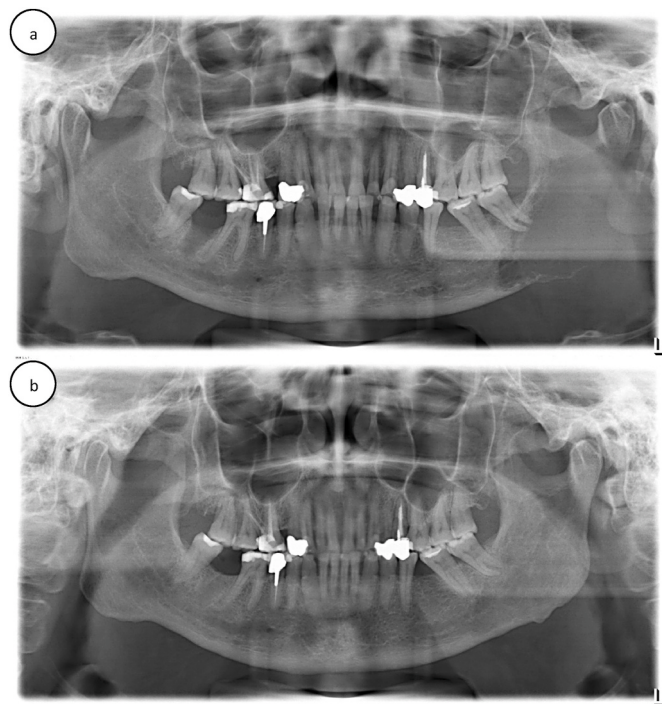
Panoramic radiograph of a 64-year old female patient with osseous metastatic breast cancer and bone metastasis in the left mandible jaw a) Extensive osteolytic metastasis in the left mandible jaw angle b) Panoramic radiograph 3 years after administration of denosumab (120 mg).
